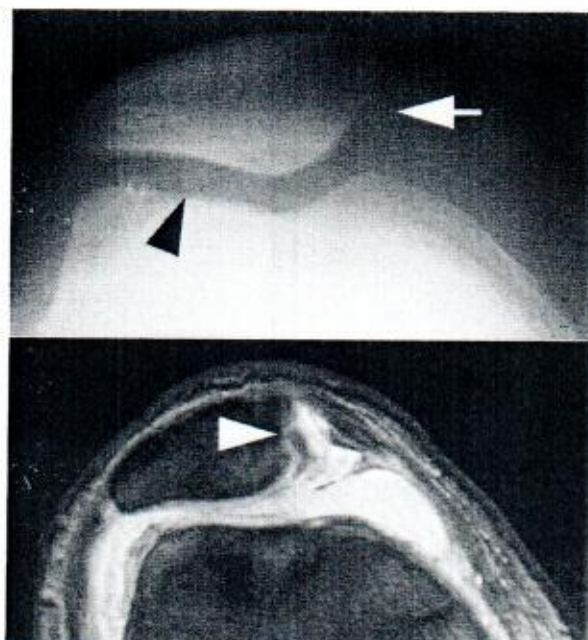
Acute primary patellar dislocation. The axial radiographic view in the standing position (above) demonstrates avulsion of an osteochondral fragment from the medial facet of the patella (white arrow) and in addition a fragment in the lateral joint space (black arrowhead). MR imaging (below) confirmed the osteochondral avulsion of the medial facet. For normal anatomy, compare with Fig. 13.6
